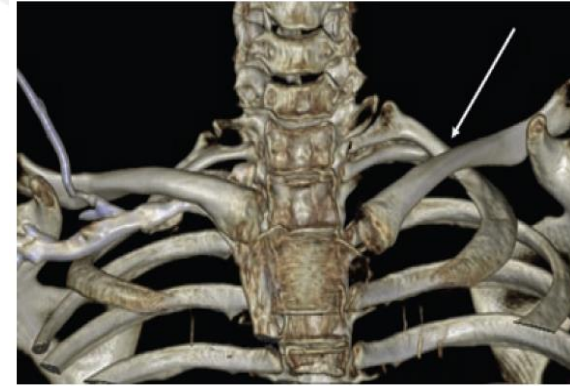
CT reconstruction showing a left anomalous first rib inserting into the second rib (arrow)
